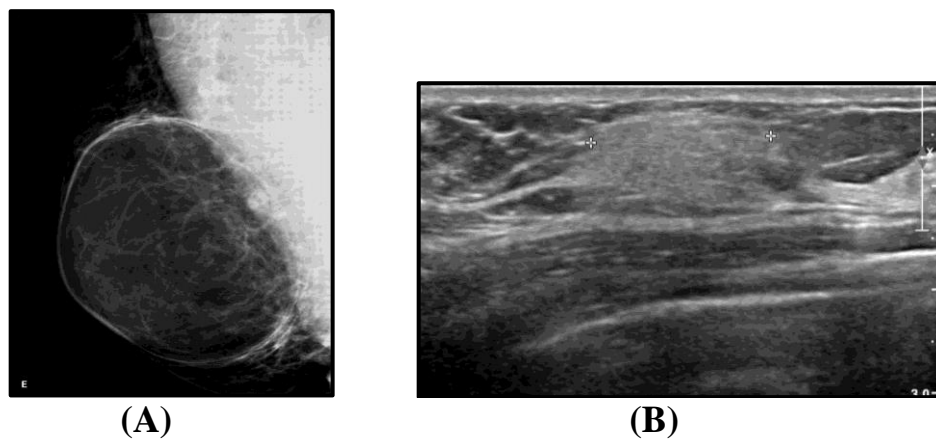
Breast lipoma mammogram (A) and ultrasound (B) (Elisabetta 2013)
